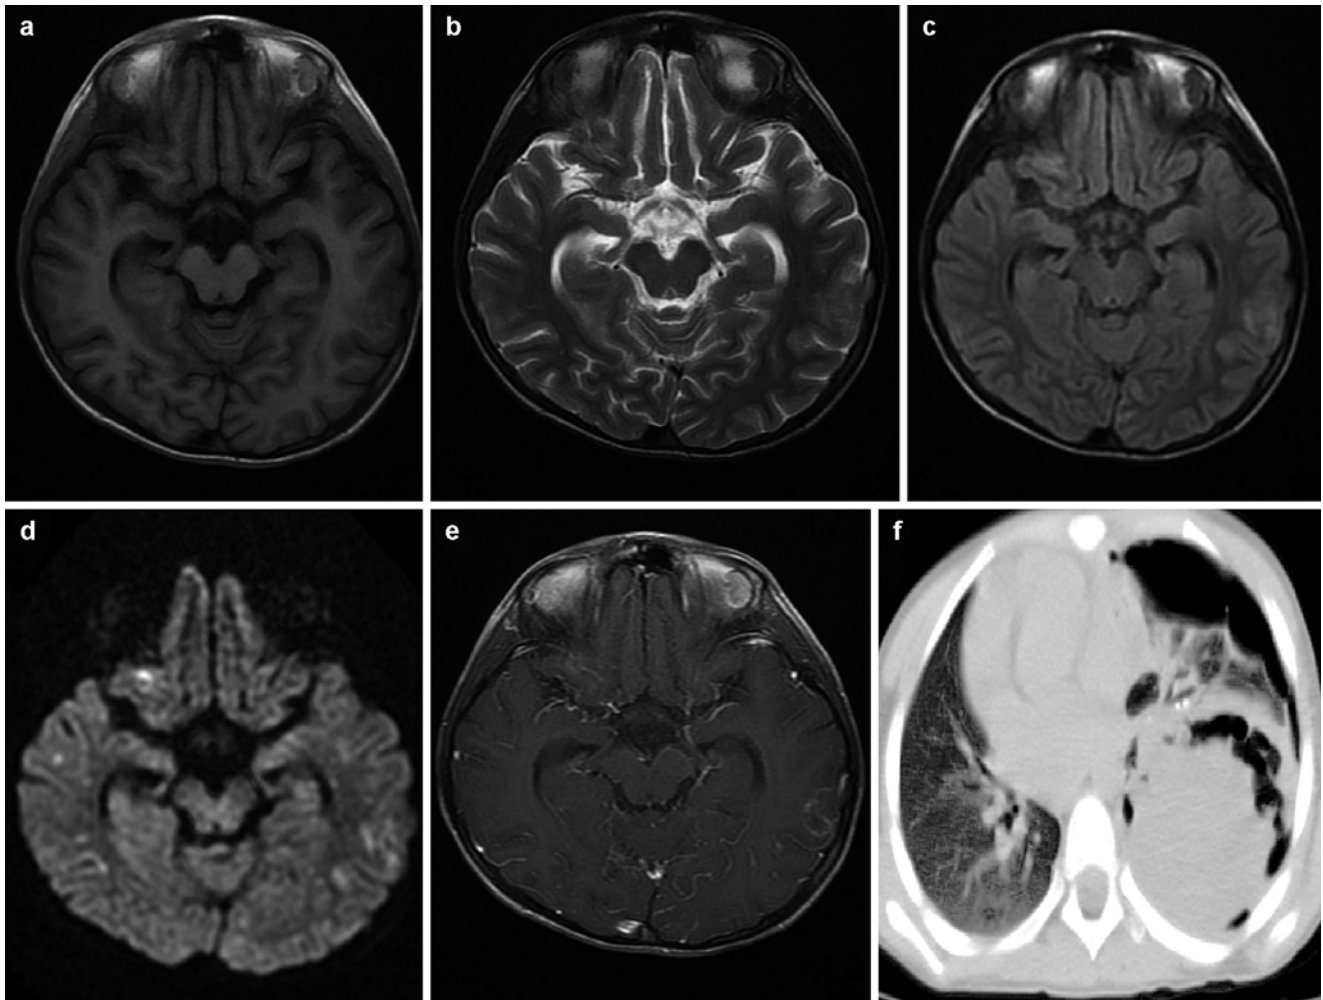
(a–f) A boy aged 8 years with influenza A (H1N1) complicated by pneumonia and intracranial mucor infection. At d 21 since onset, the patient received head MRI. (a) Round-like low signal opacity at the left temporal lobe; (b) slightly high T2WI signals; (c) slightly high FLAIR signals; (d) high DWI signals and spotlike high signals at
